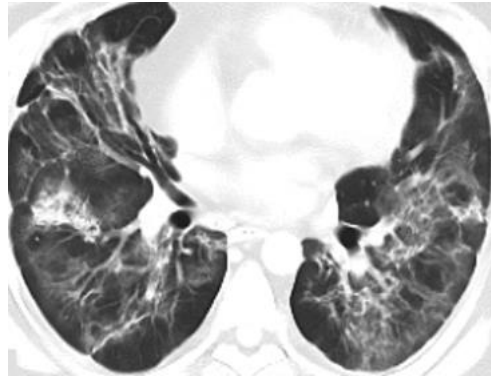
A 34-year-old man with post-COVID-19 pulmonary fibrosis showed diffuse ground glass opacification of both lungs, on axial HRCT images. Follow-up HRCT showed residual ground glass opacity and fibrotic changes.
